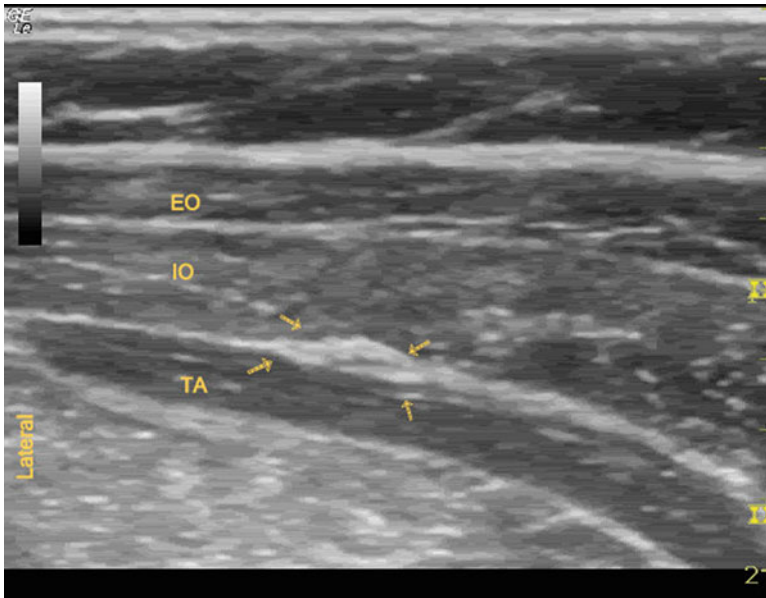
Ultrasound of the ilioinguinal and iliohypogastric nerves. The ilioinguinal and iliohypogastric nerves (*arrows*) lie in between the internal oblique (*IO*) and transverse abdominis muscle (*TA*). Also pictured is the external oblique
